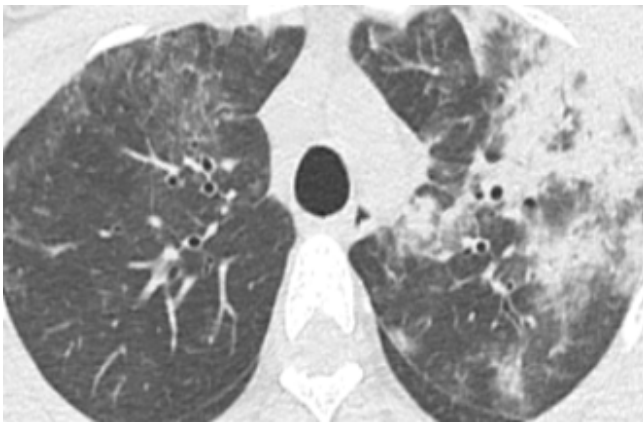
HRCT chest showing Bilateral peripheral consolidations with ground glass opacification (left more than right).
